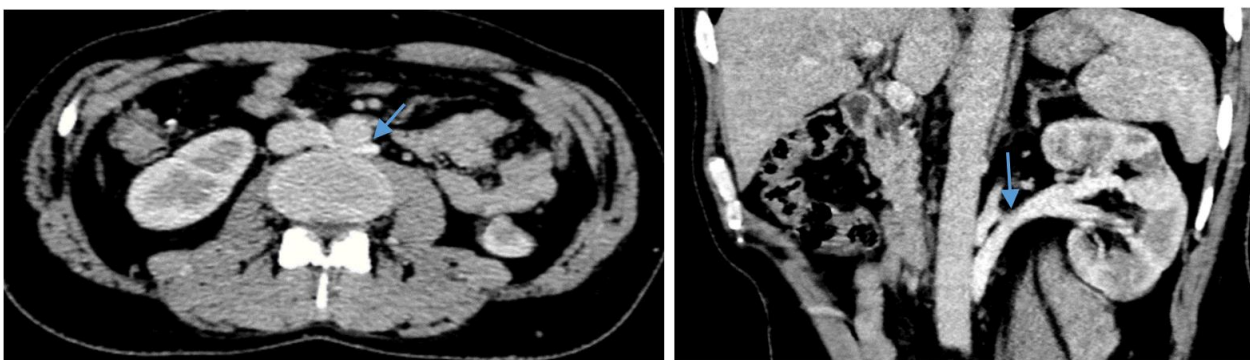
Axial and coronal CT scan with contrast injection: retro-aortic course of the left renal vein (blue arrow)
